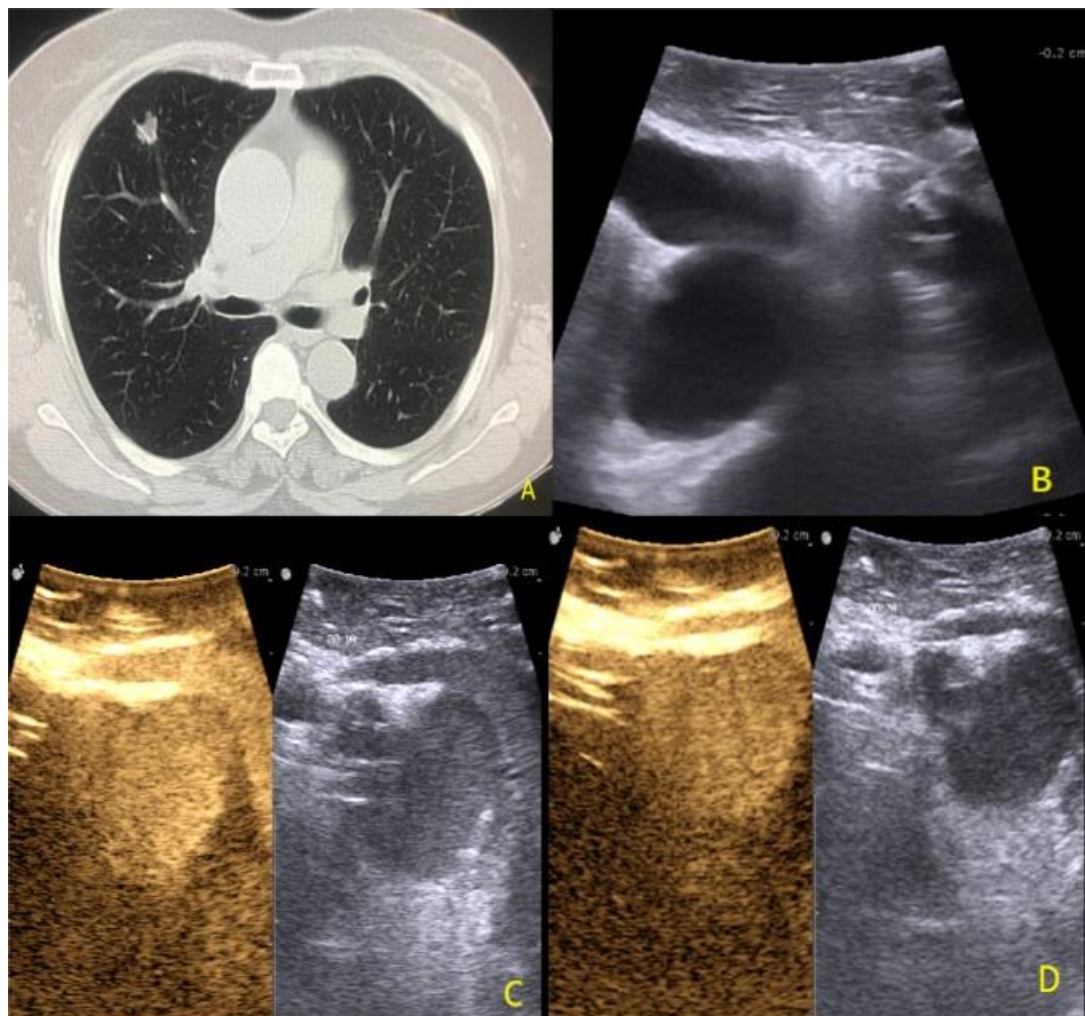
Preoperative HRCT, intraoperative ultrasonic and intraoperative contrast imaging of mGGN in the upper lobe of the right lung. A. Before operation, HRCT showed mGGN with 12mm in diameter in the anterior segment of the upper lobe of the right lung, with uneven density, irregular shape, spiny changes, shallow lobulation, and no signs of pleural traction or depression. B. Intraoperative two-dimensional ultrasonic showed that the echo of the nodule was uniform, hypoechoic, unclear boundary and irregular shape. C, D. During the operation, CEUS showed that the nodules began to enhance in 10 seconds, reached the peak in 24 seconds, enhanced from the periphery to the center, and then disappeared rapidly, showing the appearance of “slow in and fast out”. HRCT: high resolution computed tomography; mGGN: partial ground glass nodule; CEUS: contrast-enhanced ultrasonic.
